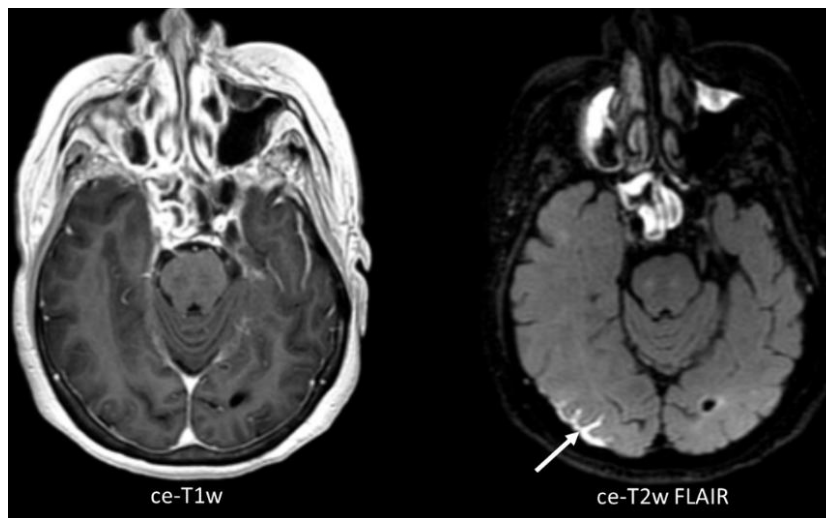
Axial view, three-dimensional (3D) contrast-enhanced T1W image (ce-T1W) on the left and T2W Fluid Attenuated Inversion Recovery image (ce-T2W FLAIR) on the right from a leptomeningeal disease patient.¹⁴
